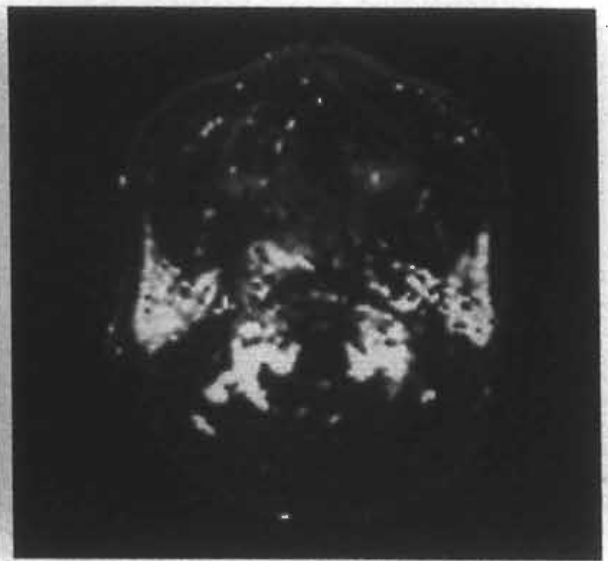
Image acquisition and processing were performed according to the protocol described in the chapter 5. Maps of DCE-MRI parameters including k_{trans} , v_e , v_p from the Tofts and Keypode model, A , k_{21} , k_{el} from the Brix model, AUC60 and AUC90 were generated.
